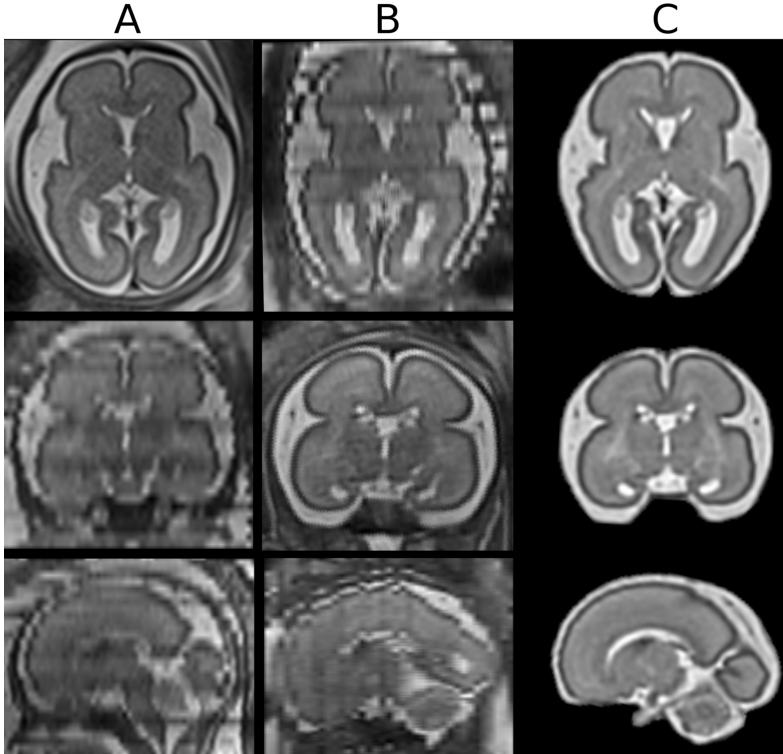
Brain MRI of a 26 GW-old healthy control reconstructed from 8 stacks of 2.5 mm slice thickness. From top to bottom: axial, coronal and sagittal views of axial (A) and coronal (B) raw stacks, and final reconstruction (C).
